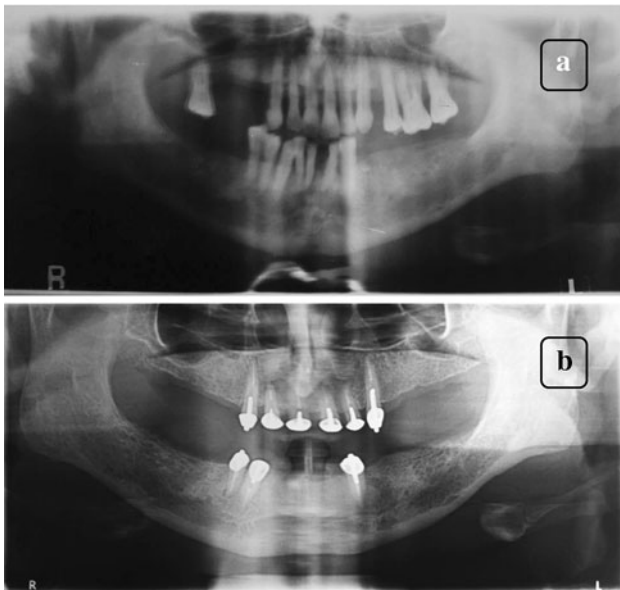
Orthopantomograph a Pre-operative, b Post-operative
